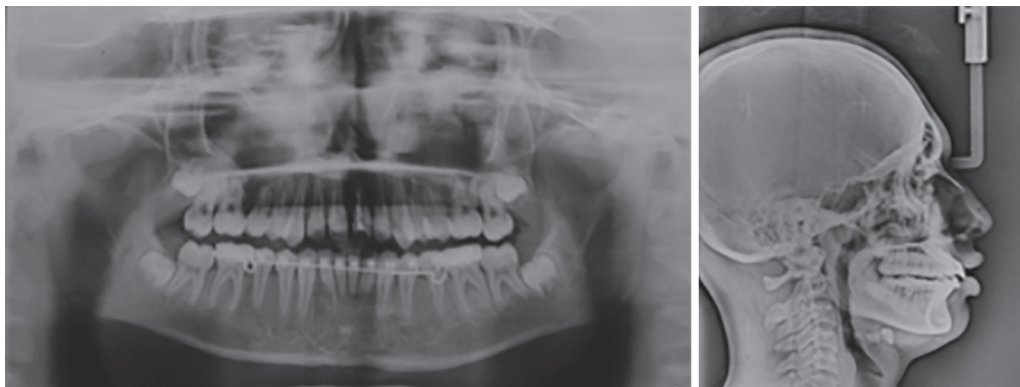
Post-Carriere radiographs
